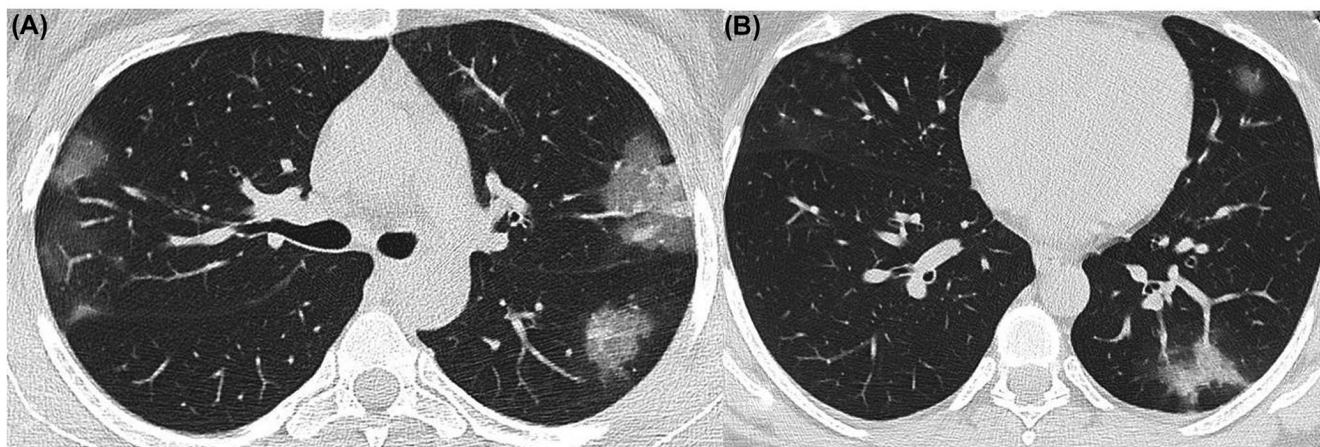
Chest CT of a 35-year-old woman with PCR-negative COVID-19 pneumonia. An axial CT image showing multiple ground-glass opacities with superimposed interlobular and intralobular septal thickening
